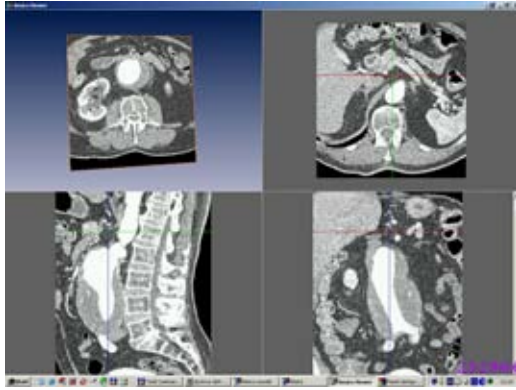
CT-angiography, four-view.
